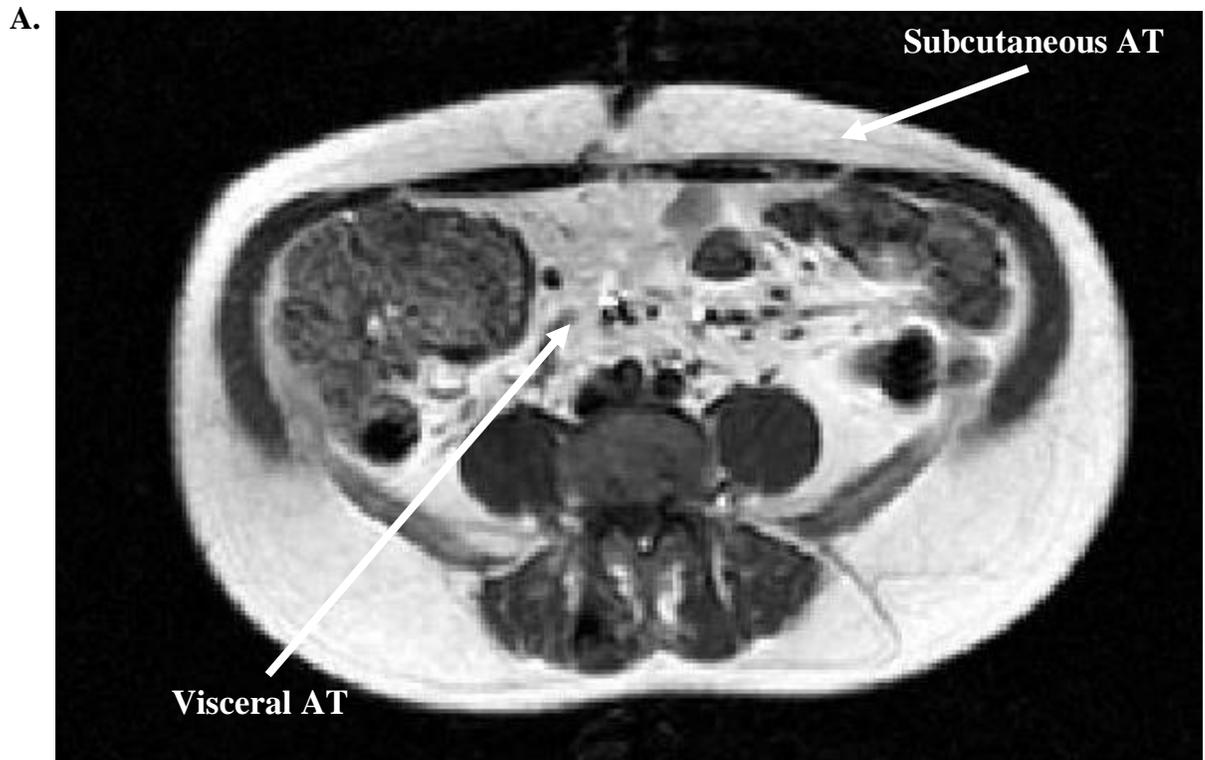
Quantification of Abdominal AT Depots Using Magnetic Resonance Imaging.
